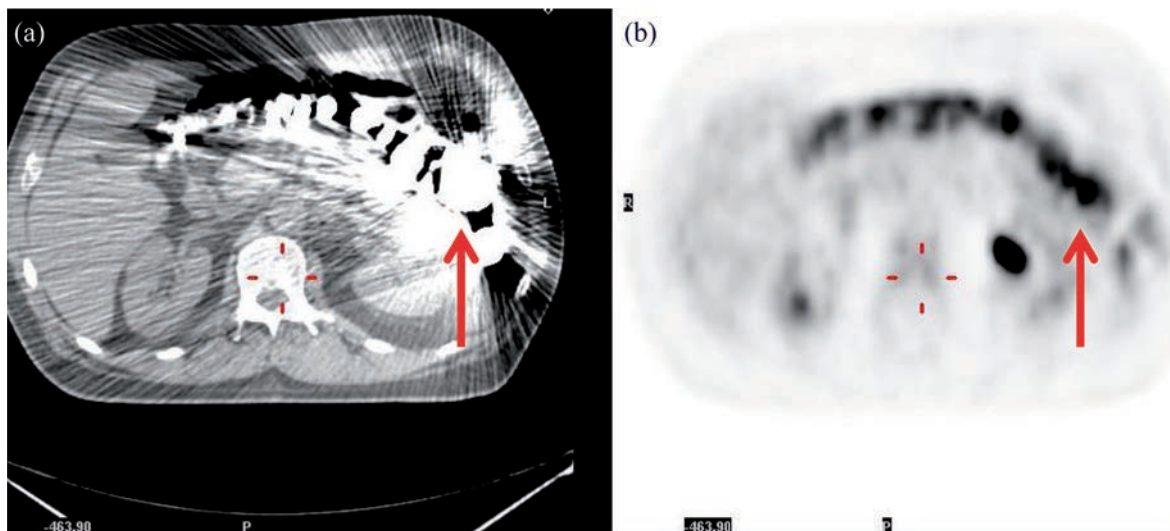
Patient undergoing whole body PET/CT imaging following an oesophagogram study. CT (a) demonstrates extensive high density (3000 HU) enhancement in the stomach propagating into artificial enhancement of activity concentration in the AC-PET images (b). AC: attenuation corrected.
